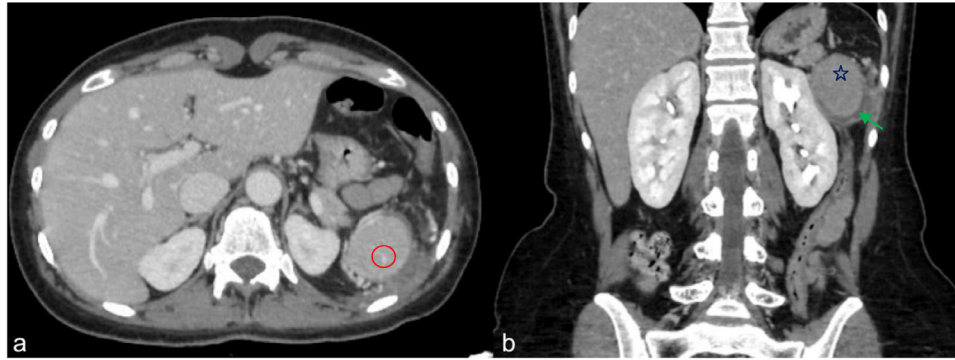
CECT Venous phase axial (A) and coronal (B) shows an accessory spleen (blue star) with a tenuous active bleeding inside (red circle) and perisplenic liquid fluid spill (green arrow). CECT, contrast-enhanced computed tomography. (Color version of figure is available online).
